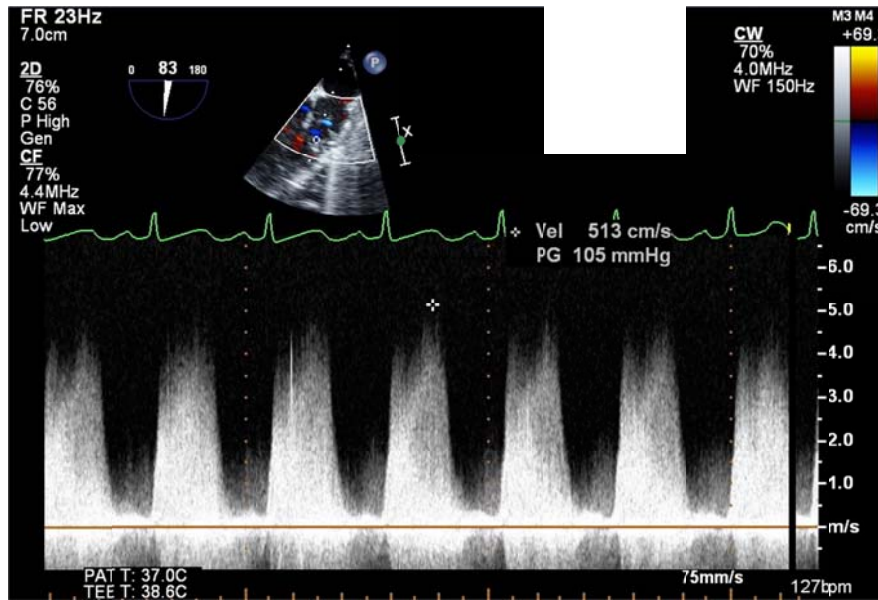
Upper oesophageal aortic arch short axis view & CW Doppler interrogation of this structure
